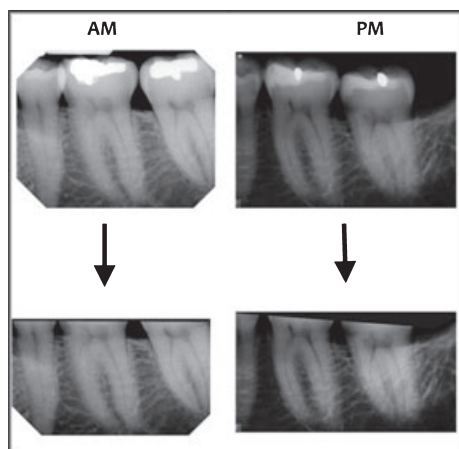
Uncropped and cropped antemortem–postmortem radiograph pair.
